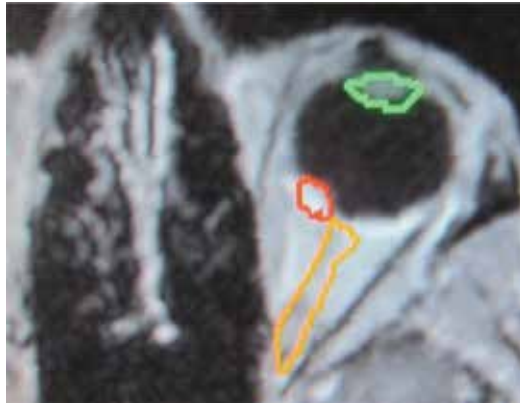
MRI scan of eye globe with uveal melanoma (choroidal melanoma stage T1b)—red color, lens—green color, optic nerve—yellow color.
